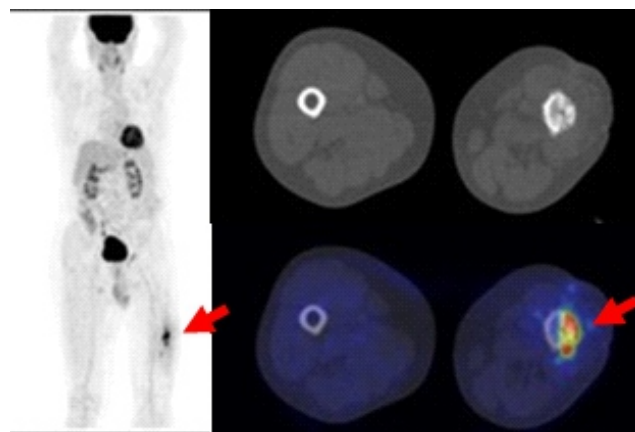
A 59 year old man with left femur fracture treated with surgery and complicated by osteomyelitis unresponsive to antibiotics. Fluorine-18-FDG PET/CT: typical hypermetabolic lesion in the left femur and contiguous soft tissues.
